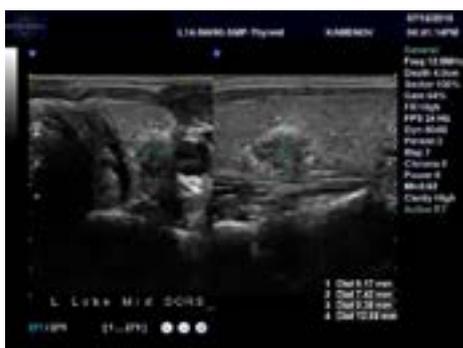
Ultrasound appearance of the thyroid nodule in our case.
